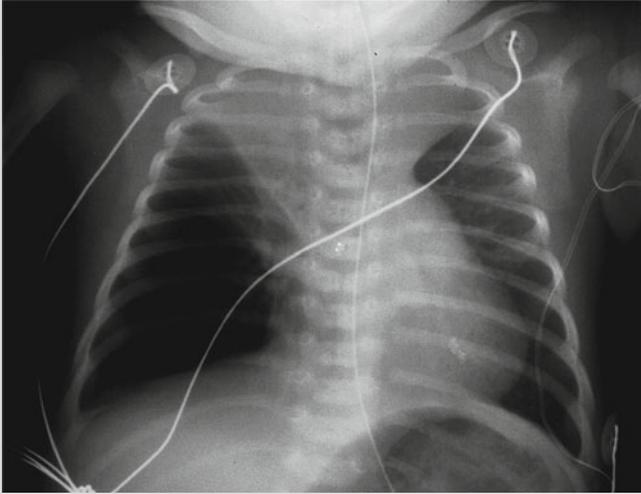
Chest radiograph at 7 days of age showing severe hyperinflation and bilateral upper lobe volume loss
